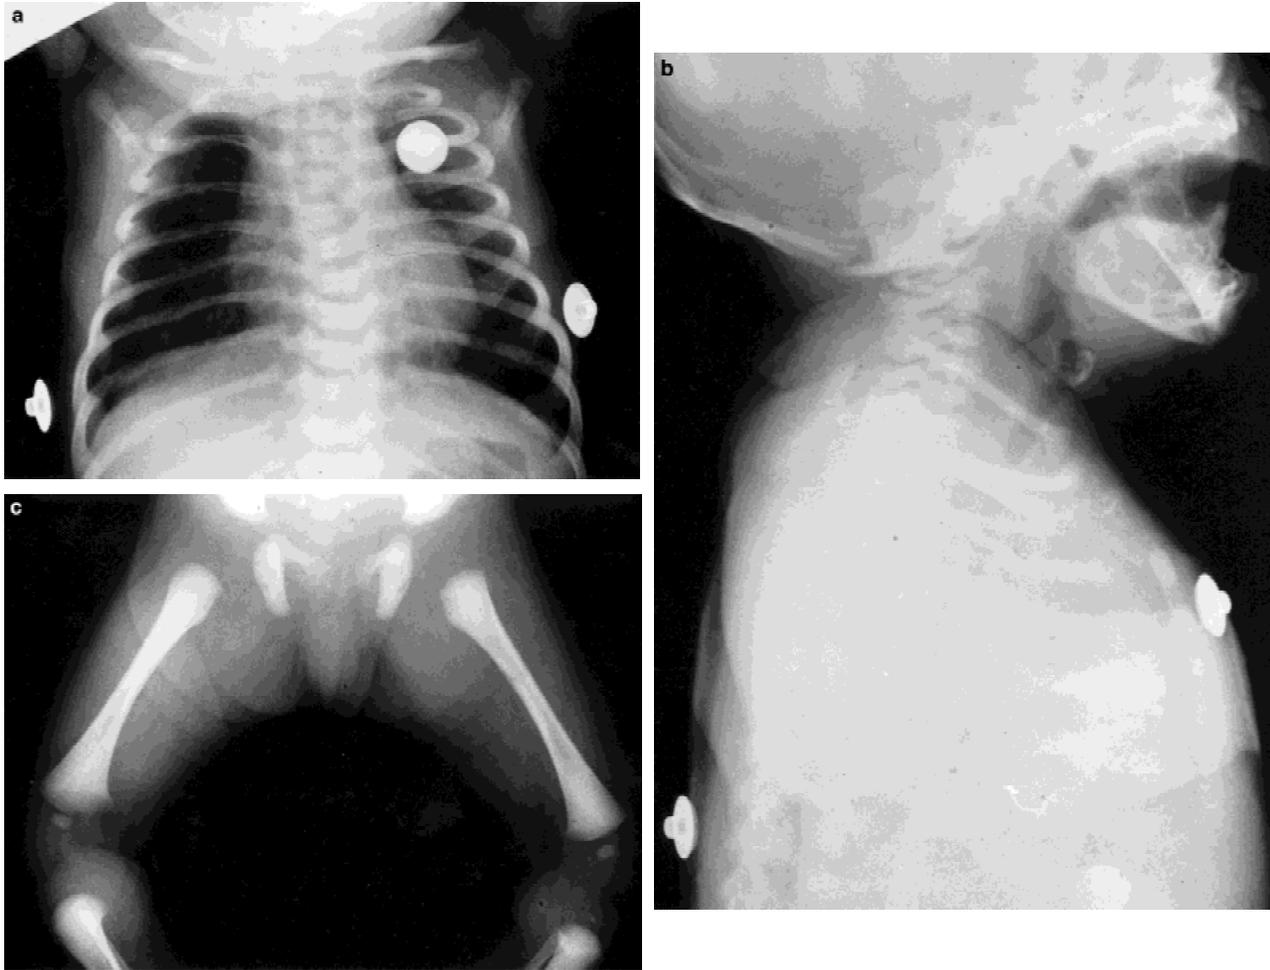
Radiographs of patient 2 on the second day of life. a: Very pale radiodense stipplings are seen at the costochondral junction of several ribs. Note defective ossification of T-7, T-10, and mild scoliosis. b: Radiodensities are better demonstrated in the lateral views of the sternum and laryngeal cartilage. c: There are a few stipplings in the sacrum.
